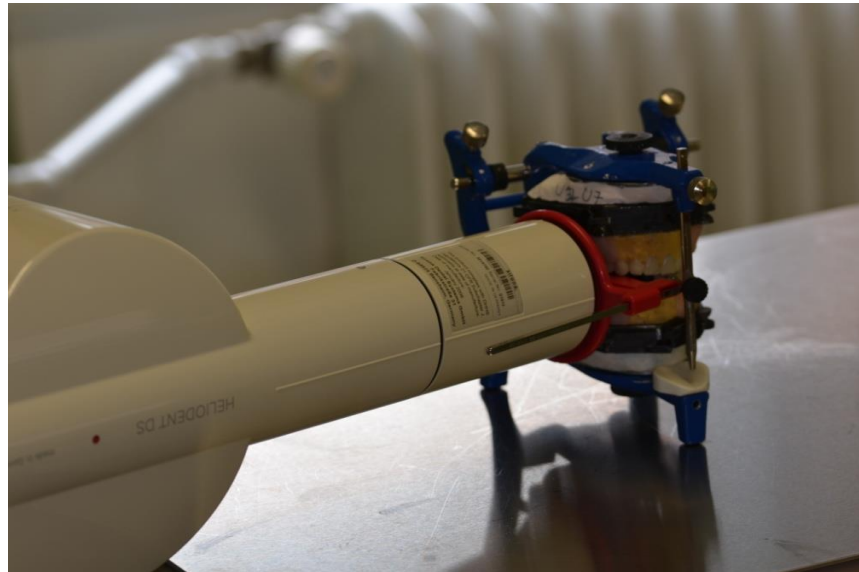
Digital Bitewing Radiograph technique for a pair of arches mounted on an articulator.
